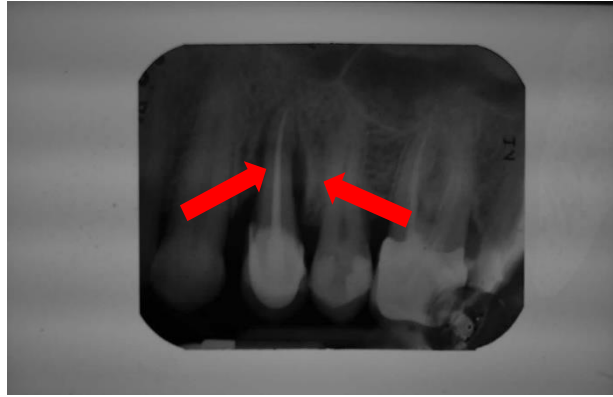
X-ray after the twelfth session: initial volumetric reduction of the radiolucent area (arrows) can be seen.
